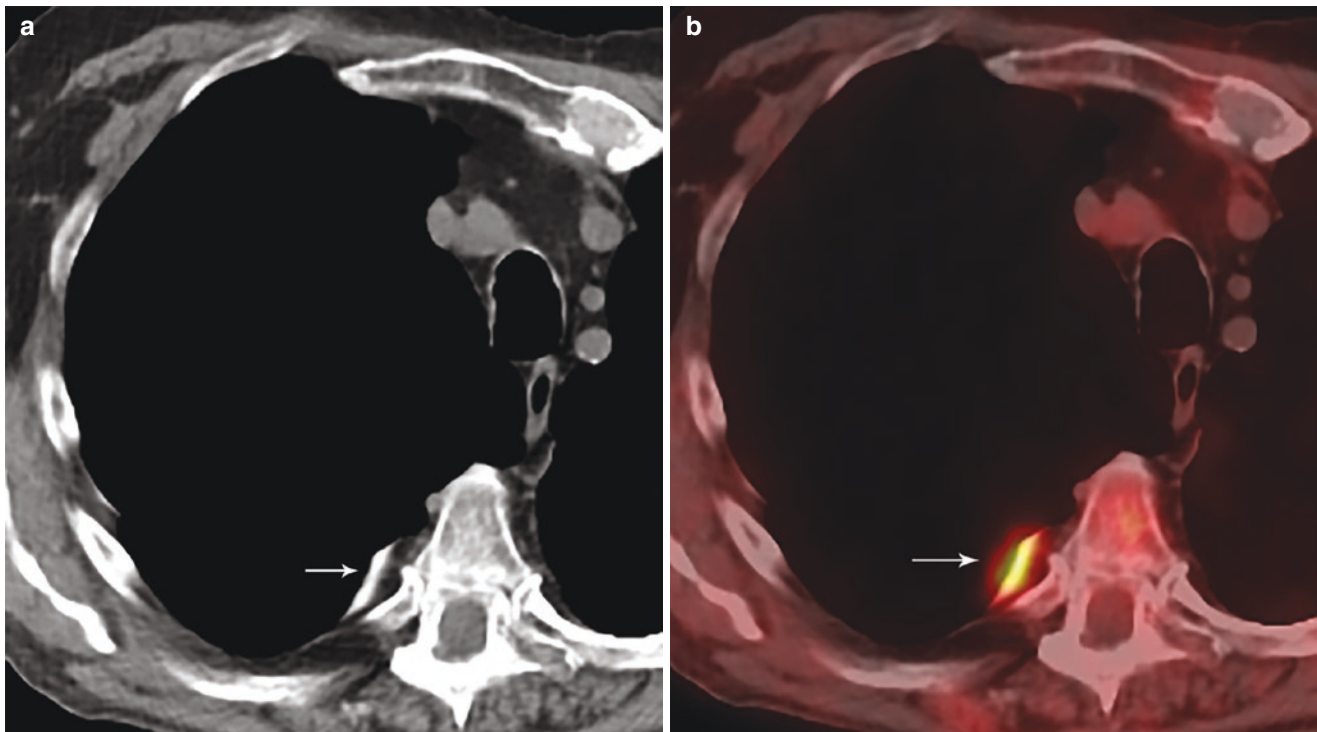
(a) Non-contrast axial CT shows high attenuation material in the posterior right pleural space (arrow) consistent with talc pleurodesis. (b) axial PET/CT shows increased radiotracer uptake in the talc deposits
